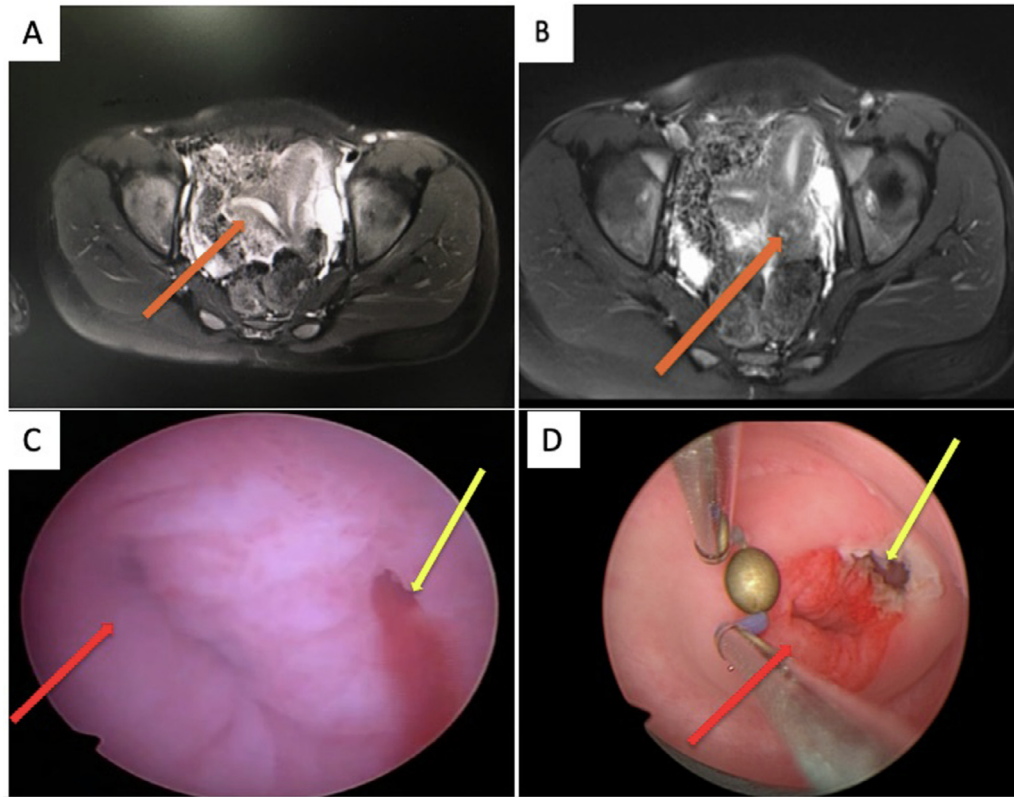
(A) Pelvic MRI showing septate uterus (orange arrow), (B) two cervical canals (orange arrow); (C) inspection of the cervix revealed a normal appearing external cervical os (red arrow) on the right with a slight bulging in left side of the cervix (yellow arrow) due to accumulation of old retained menstrual blood, seen at the beginning of vaginoscopy using a hysteroscope, (D) dilated cervical os at the end of the vaginoscopy combined with hysteroscope (yellow arrow; red arrow is the normal right cervical os).
